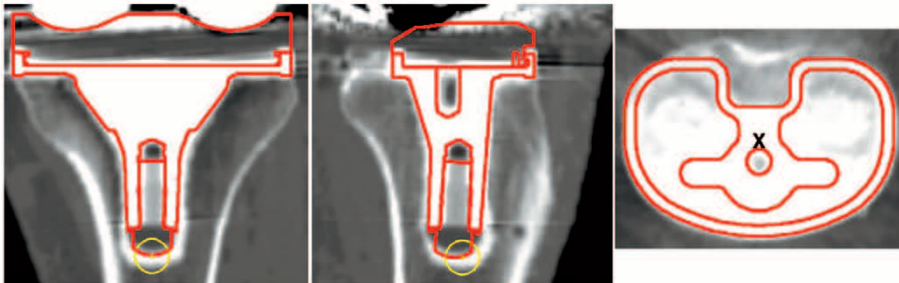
Postoperative CT displaying the implanted tibial component. The outline of the virtual component is positioned and superimposed on the real component in all planes by repeatedly scrolling through the volume, until real and virtual outlines appear congruent. The same procedure is performed for the femoral component, and the relevant parameters are measured for a second time, as seen in Figure 1.
